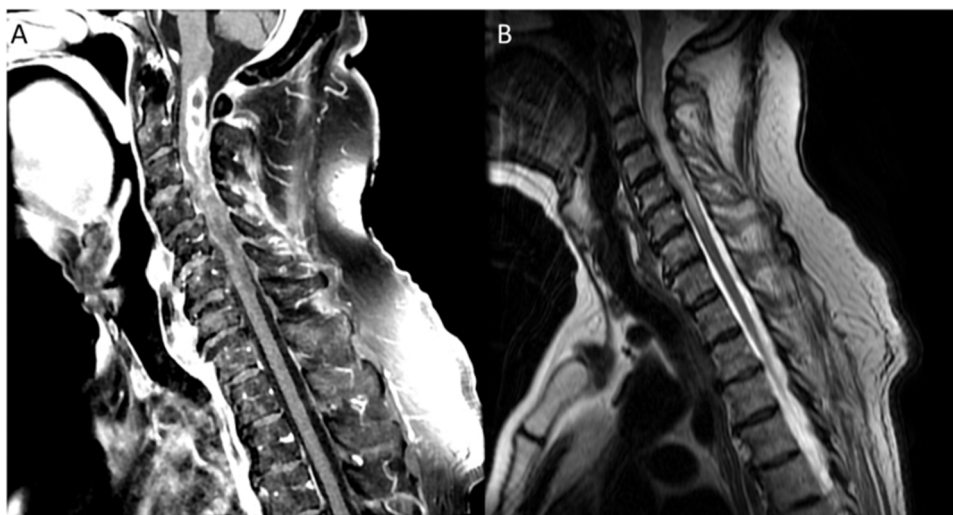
MRI T1 weighted imaging revealing spinal cord hypoattenuation at the skull base with further extension to C5 concerning for internal necrosis (A) and redemonstration of diffuse hyperattenuation on T2 weighted imaging (B).
